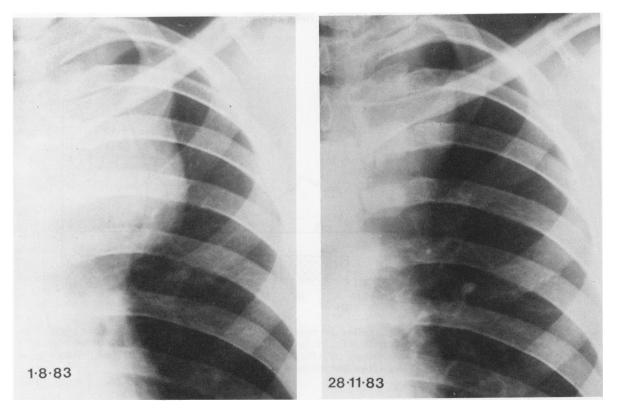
Part of chest X-ray before and 4 months after starting recombinant leukocyte A IFN.
